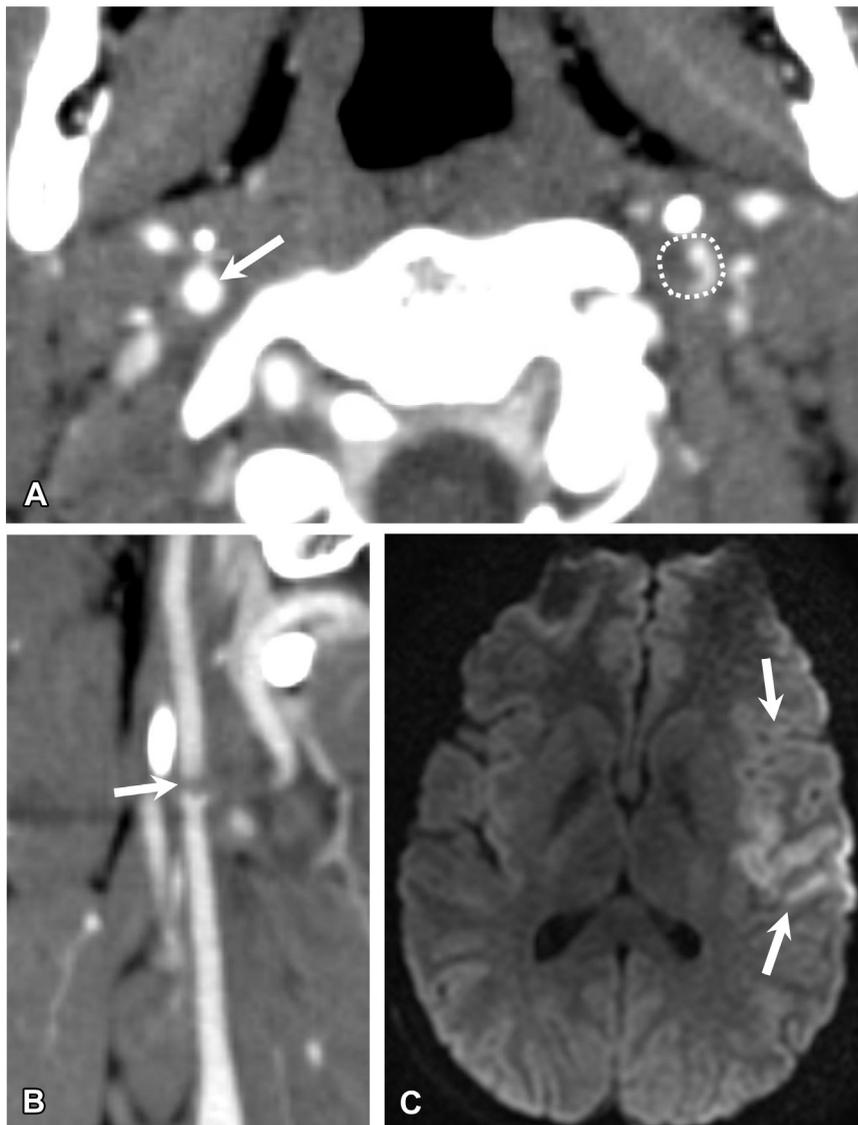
Case 1, initial presentation. Computed tomography angiogram of the neck in (A) axial and (B) sagittal planes, and (C) axial diffusion-weighted magnetic resonance image (DW-MRI) of the brain at the level of the basal ganglia. The dotted circle in (A) delineates the contour of the cervical segment of the left internal carotid artery (ICA). Note the filiform contrast-opacification of the lumen (white content) secondary to the presence of a dissection with a thrombosed false lumen (dark content). The white arrow in (A) points the normal contralateral ICA. The arrow in (B) points to the dissection flap in the cervical segment of the left ICA. DW-MRI of the same date shows restricted cortical diffusion on the vascular territory of the third segment of the left medial cerebral artery consistent with an acute ischemic infarct (arrows in C).
